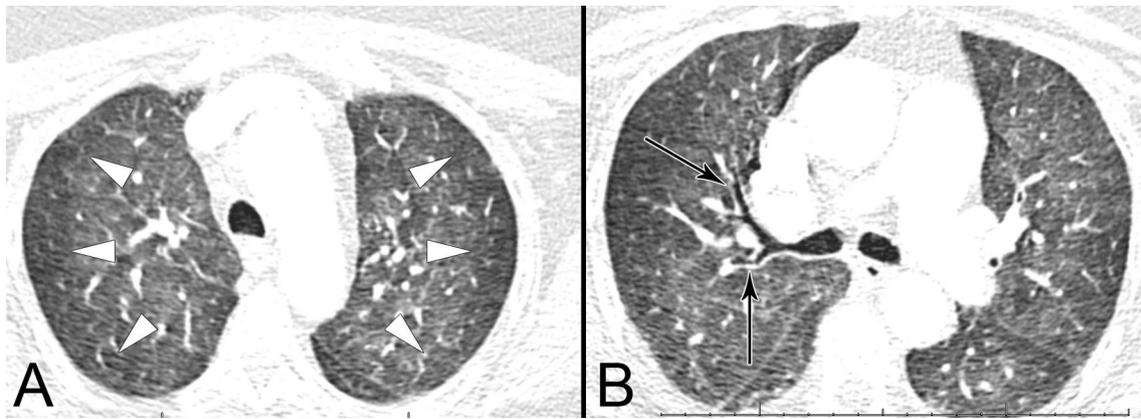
Computed tomography images of patient 5 showing areas of ground glass opacity (pulmonary alveolar edema), which respect the subpleural space (A: arrowheads). There is also thickening of bronchial walls (B: arrows).
